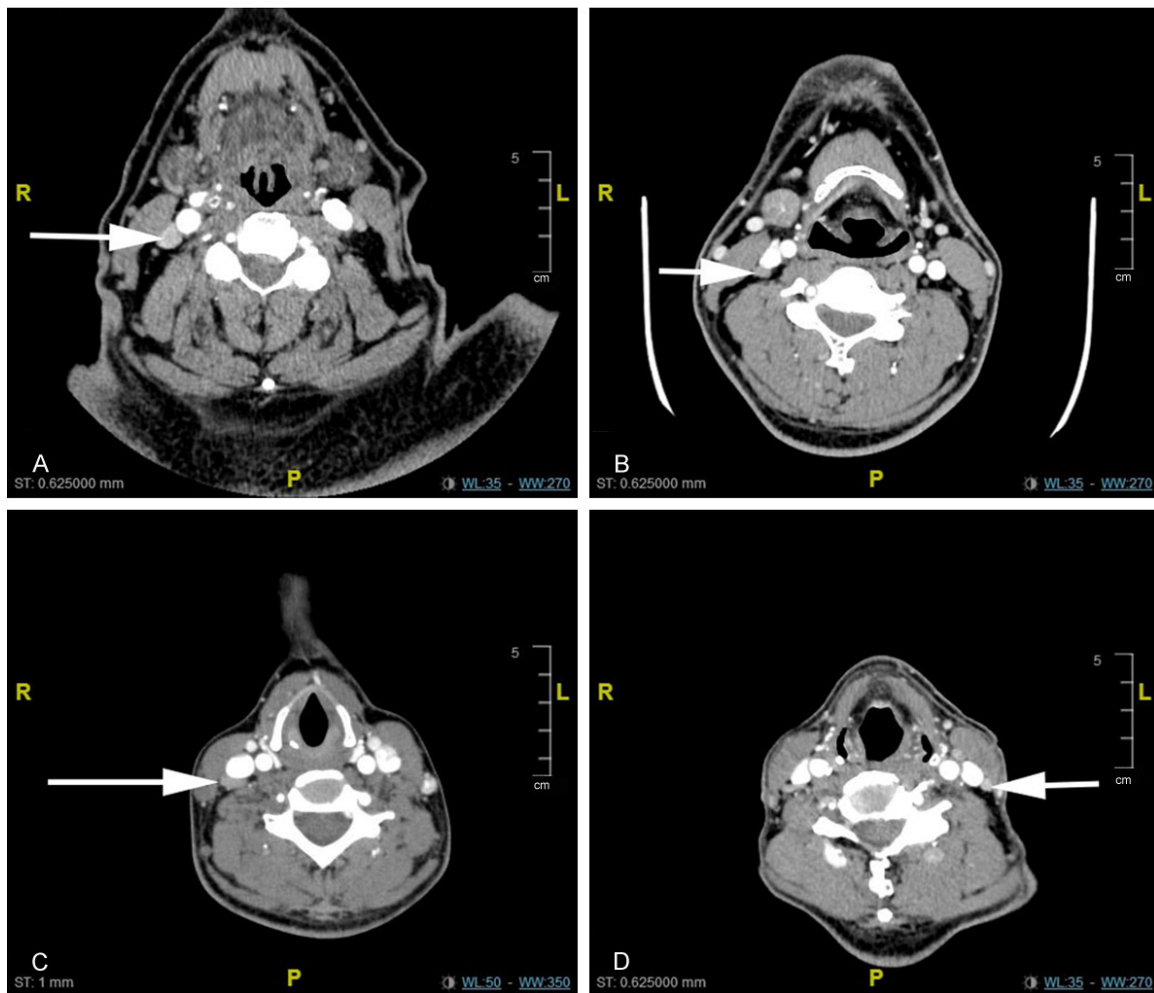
(A-D) preoperative CT of patients with positive IIb lymph nodes. Arrows indicated positive lymph nodes of level IIb.
